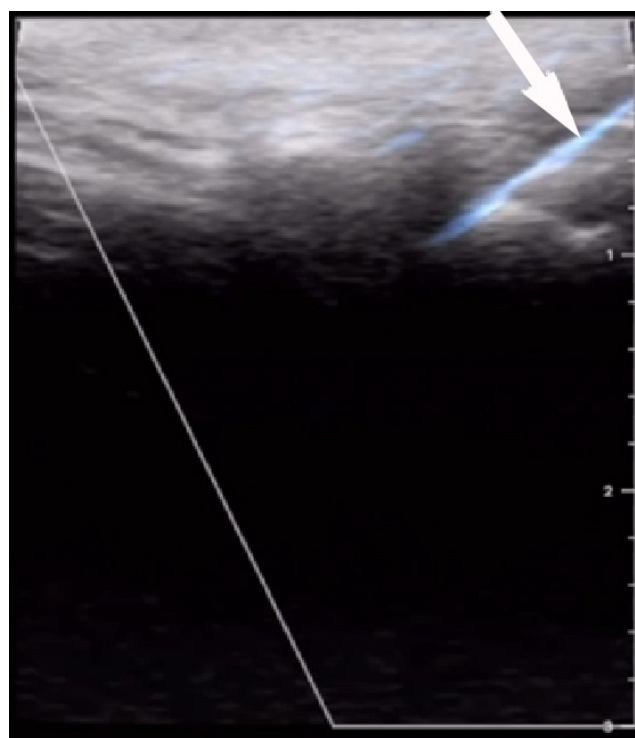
In-plane needle insertion for lower joint space injection under ultrasound (US) guidance (the needle can be seen in light blue and is marked with a white arrow for academic reasons)
